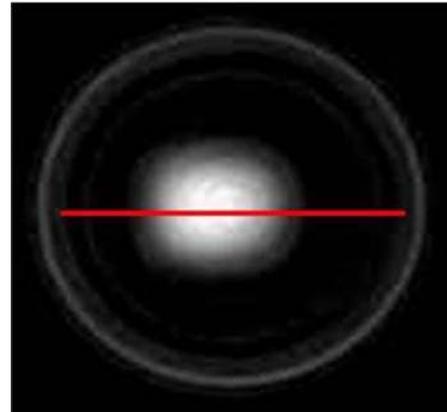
2D Subtracted Image of CT Reconstructed Slices of Post irradiated gel.
